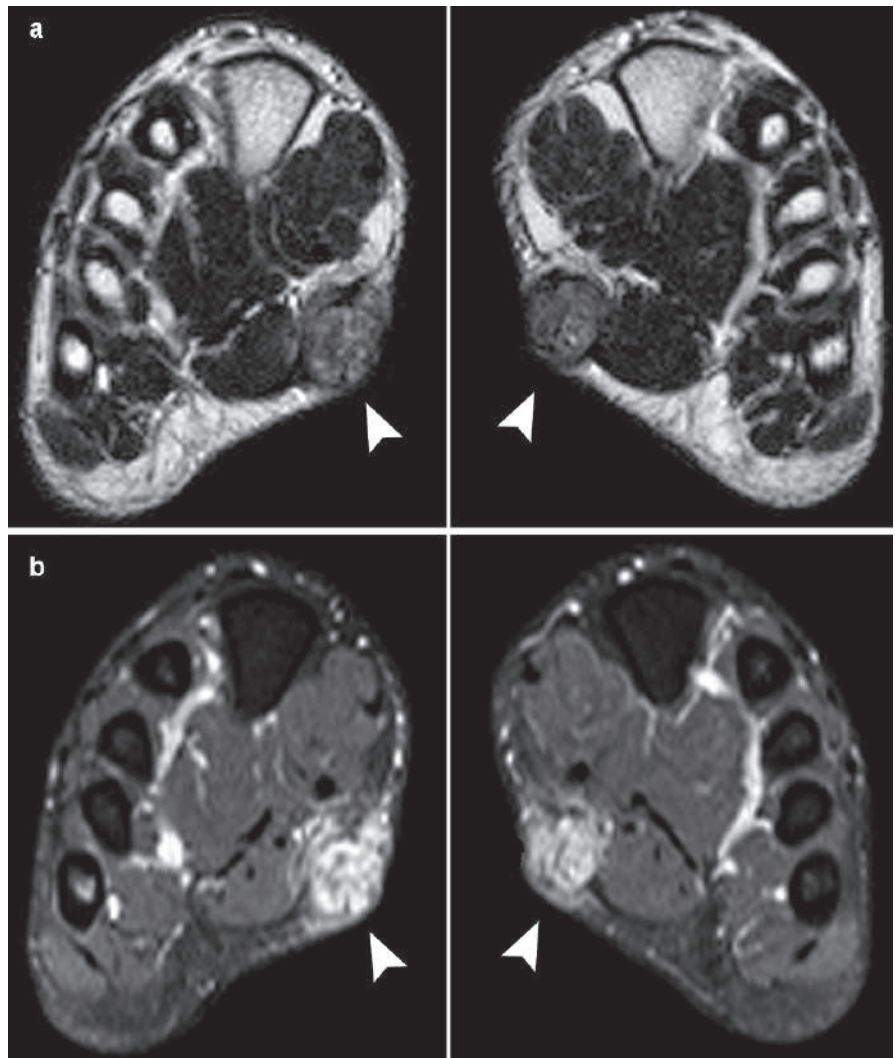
Axial-oblique T2W (a) and T1W post-contrast MRI of the feet shows bilateral hypointense plantar masses (*arrowheads*) on image (a) diagnostic of Ledderhose disease (plantar fibromatosis). The masses show marked contrast enhancement after gadolinium injection (b)
